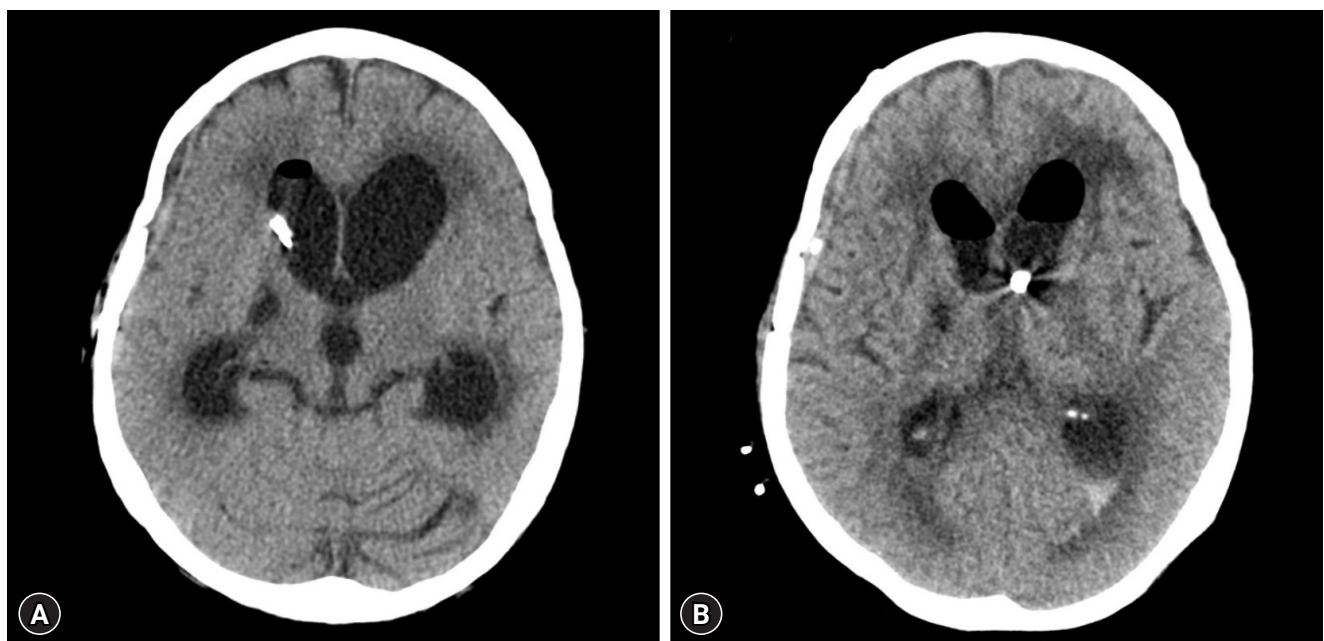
Brain computed tomography (CT) images before and after endoscopic irrigation and septostomy. (A) Preoperative CT image. (B) Postoperative CT image. On the postoperative CT images, a reduction in ventricular size compared to the preoperative CT images was observed.
